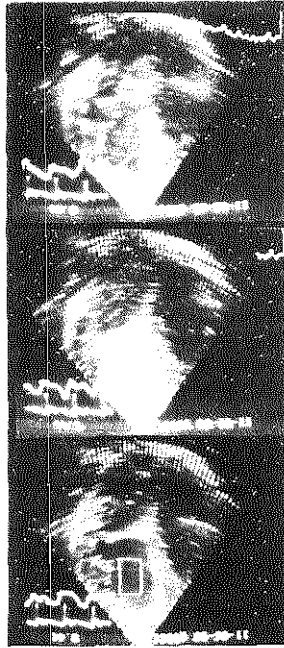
Upper panel: a rectangular sample area has been designated within the left ventricle. Apical four-chamber view. This frame is immediately prior to contrast opacification after a catheter left ventricular injection. Middle panel: the outline of the sample area is seen faintly during maximal contrast intensity. Note simultaneous display of cumulated videodensity at lower left of panel. Lower panel: The left ventricular contrast has nearly been cleared at the end of the injection.
